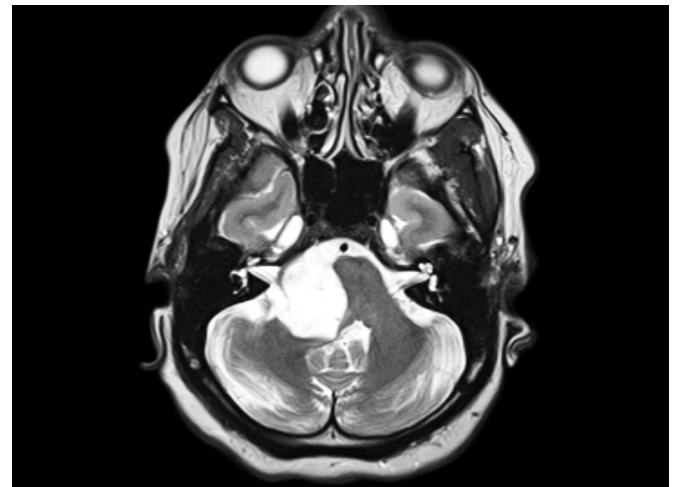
Cerebellopontine angle (CPA) epidermoid. Axial T2-weighted magnetic resonance imaging (MRI) of a CPA epidermoid demonstrating hyperintensity. Note cranial nerves VII and VIII visible in the internal auditory canal.
